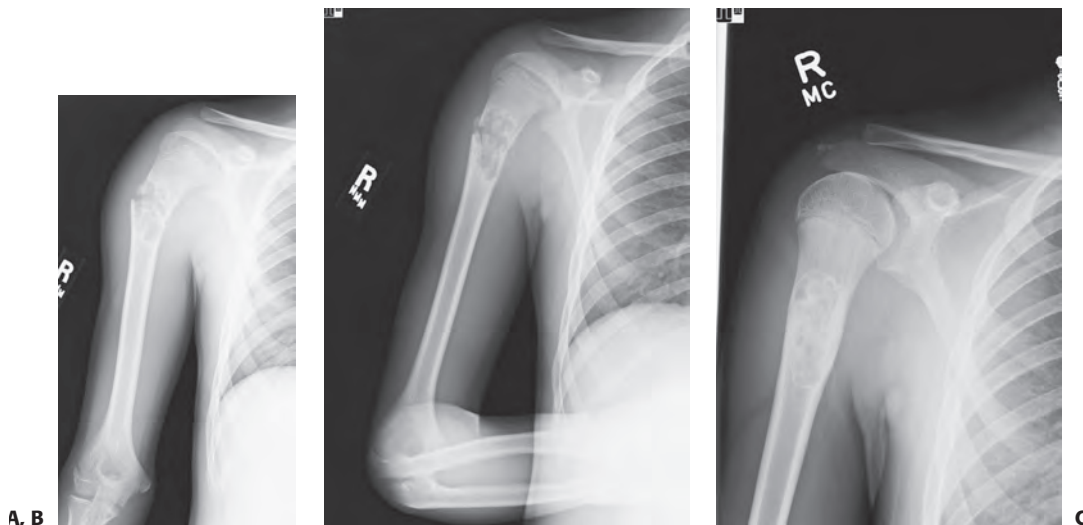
A 13-year-old girl sustained a fall from her own height and developed pain and deformity around the right shoulder. Anterior–posterior (A) and lateral (B) plain films show a pathologic fracture through a well-defined, eccentric, cortical based lesion in the proximal humerus metaphysis. There is sharp sclerotic rim and the lesion was clinically diagnosed as nonossifying fibroma. After 4 weeks of conservative treatment, the fractured healed (C, D) in a few degrees of varus and the lesion persisted.
